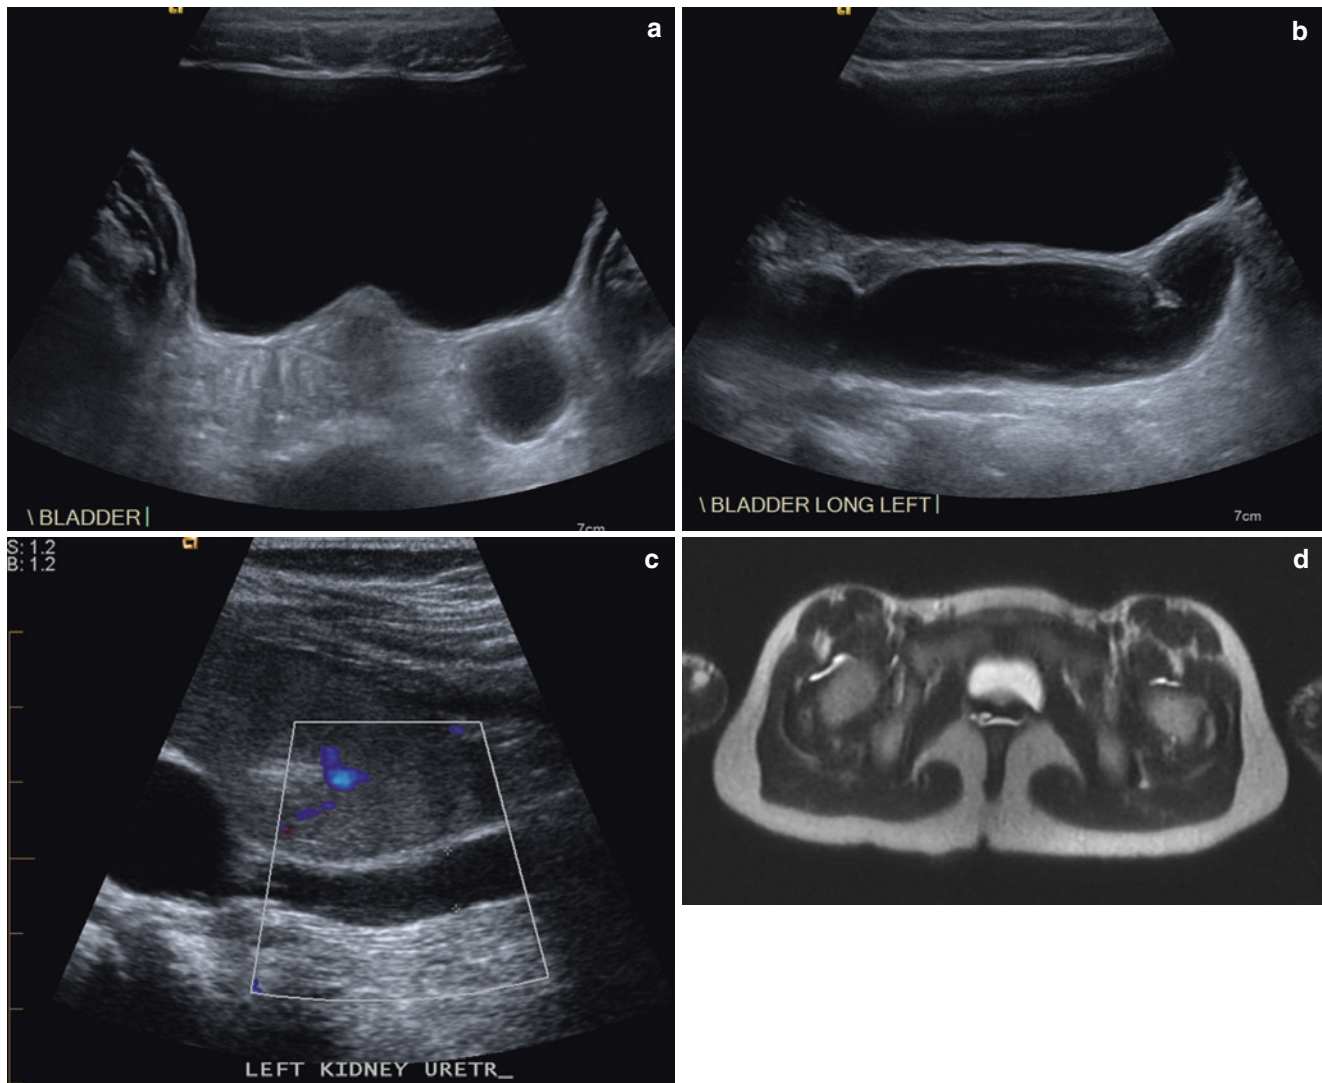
(a) Transverse ultrasound image of the bladder with a dilated left distal ureter appearing as a rounded hypoechoic structure posterior to the bladder. (b) Longitudinal ultrasound image showing a dilated distal ureter as a tubular structure posterior to the left side of the bladder. (c) Longitudinal ultrasound image of a dilated proximal ureter. (d)
